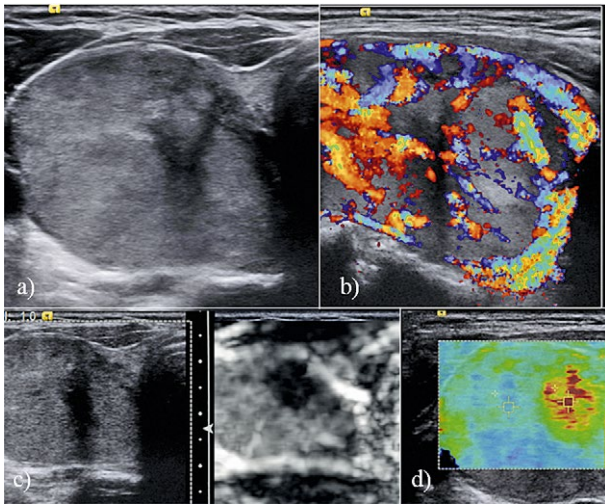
A 61 year old female with a 3.2 cm hypoechoic nodule seen in the right lobe on transverse image (a) that has markedly increased blood flow on color Doppler (b), a very stiff nodular component on strain elastography (c). On 2D-SWE (d) the nodule within the lesion had a stiffness value of 7.0m/s while the majority of the lesion has a stiffness of 2.28m/s. On biopsy the nodule was diagnosed to be a papillary carcinoma
